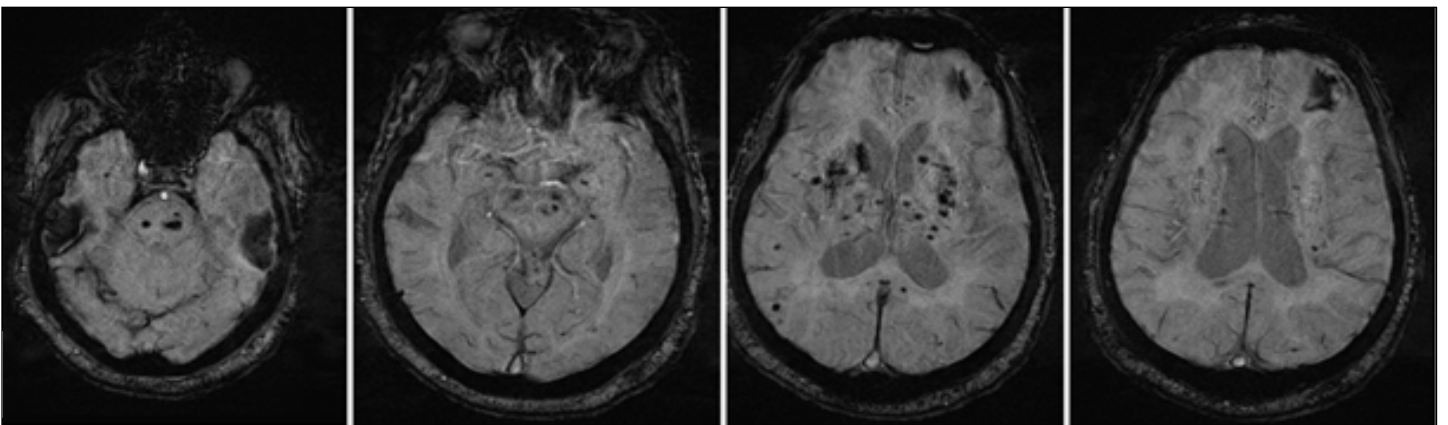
MRI brain SWI images revealing widespread subcortical microhemorrhages suggestive of ischemic hypertensive lesions and/or cerebral amyloid angiopathy.
